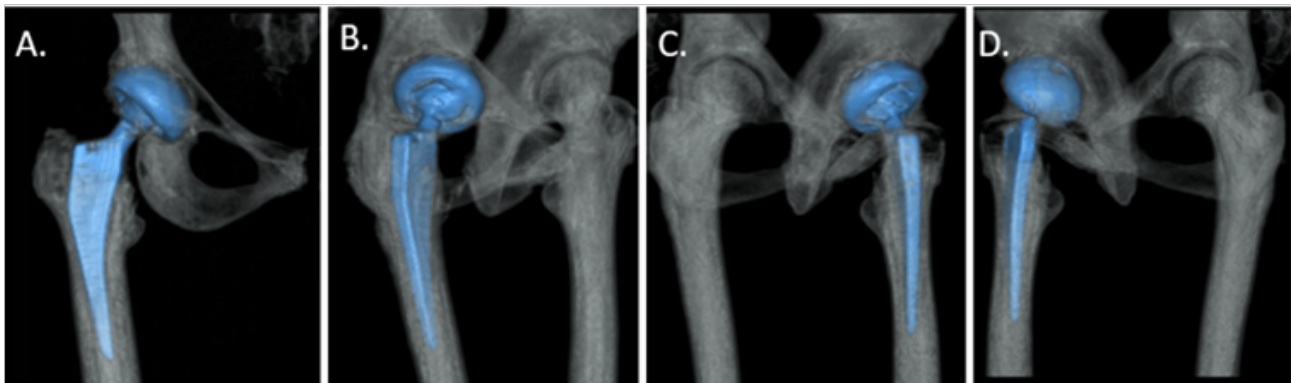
(A) to (D) are 3D reconstructions with metal suppression from a CT scan of the right hip in AP, lateral, internal oblique, and external oblique projections, respectively. Adequate bone coverage of the acetabular component is observed in the superolateral and anterior regions.
